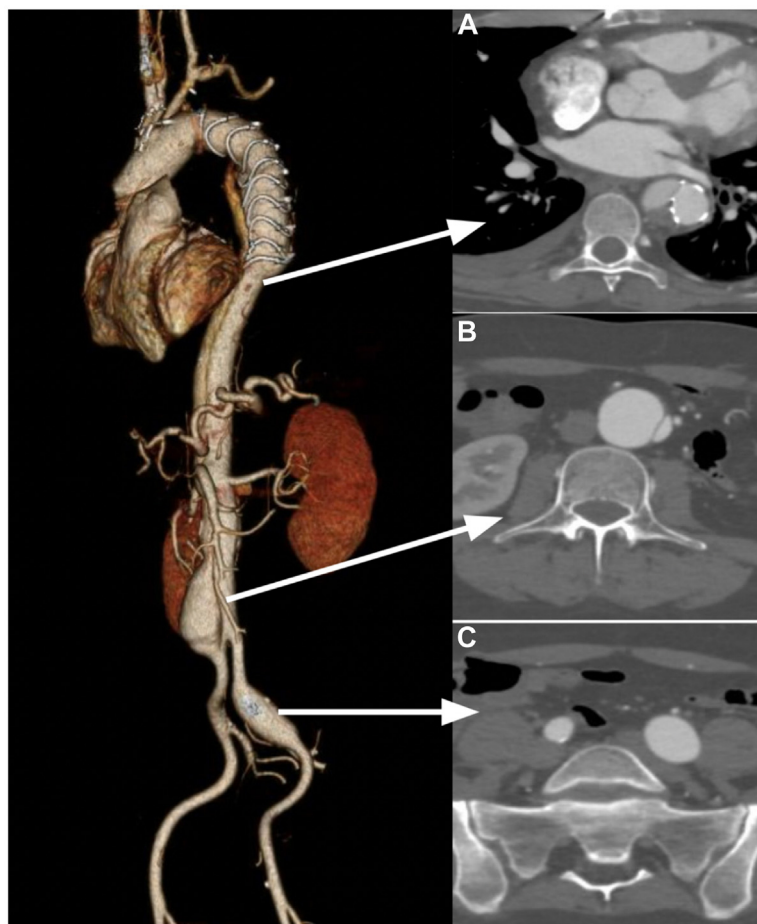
Computed tomography angiography (CTA) after zone 2 arch replacement with a frozen elephant trunk axial view demonstrated (A) residual dissection of the distal thoracic aorta with lack of distal seal (A), an infrarenal abdominal aortic aneurysm (B), as well as a left common iliac artery aneurysm (C).
